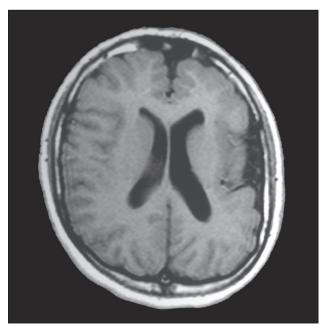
Axial T1-weighted MRI sequence showing left frontoparietal PMG with ipsilateral hemisphere atrophy in a 10-year-old boy.
